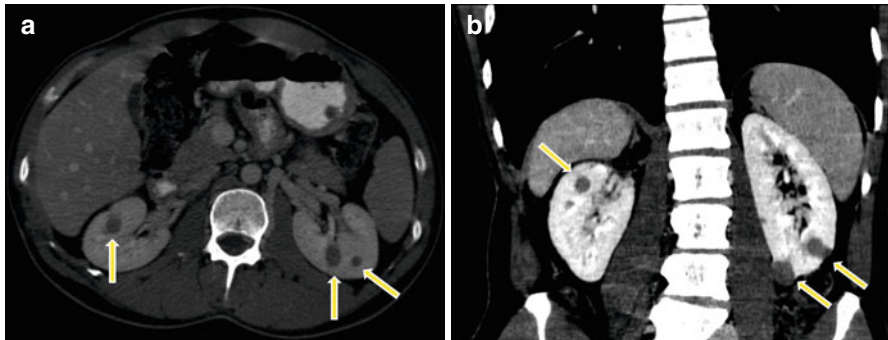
(a) Bilateral multifocal hypointense renal lesions, axial view. CT scan of the abdomen and pelvis in a 40-year-old male with HPRC demonstrating multiple, bilateral, hypointense renal lesions. Same patient as (b), in axial view. (b) Bilateral multifocal hypointense renal lesions, coronal view. CT scan of the abdomen and pelvis in a 40-year-old male with HPRC demonstrating multiple, bilateral, hypointense renal lesions. Same patient as (a), in coronal view
